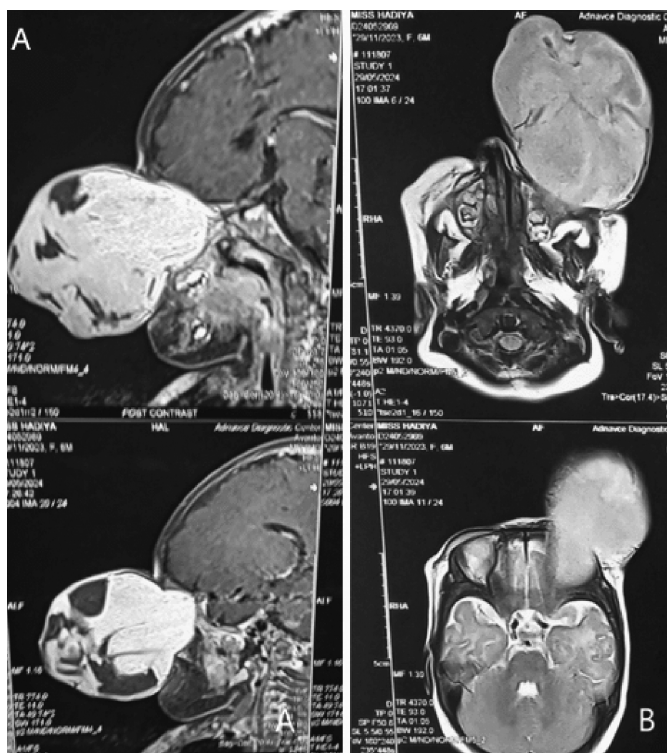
MRI sagittal view and axial views of howling hyperintense lesion extending up to the left orbital apex.
